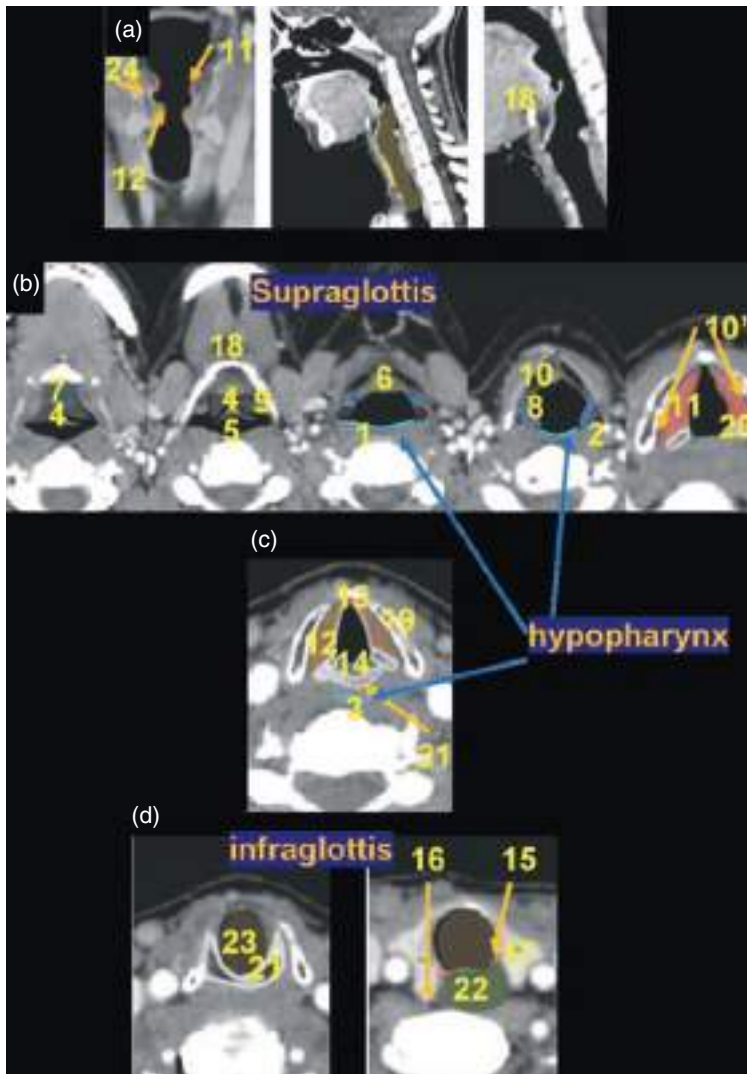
Larynx. (a) Coronal (left) and sagittal views (middle and right) of the larynx in the midline, with detail of the laryngeal ventricle and the pre-epiglottic space in the coronal and sagittal planes, respectively. (b) Axial contrast-enhanced CT images of the supraglottic space. (c) Axial noncontrast CT image at the level of the glottis. (d) Axial contrast-enhanced CT images at the infraglottic level. Hypopharynx: formed by 1, posterior pharyngeal wall; 2, pyriform sinus; 3, post-cricoid region. Supraglottis: 4, epiglottis with glossoepiglottic fold and valleculae located on both sides; 5, free edge of the epiglottis; 6, base of the epiglottis; 7, base of the tongue; 8, aryepiglottic folds; 9, pharyngoepiglottic fold; 10, pre-epiglottic space; 10', paraglottic space, which also extends to the glottis; 11, false vocal cords or bands. Glottis: 12, vocal cords, the vocal ligament lies more medial; 13, anterior commissure; 14, posterior commissure; 10', paraglottic space. Other structures: 22, esophagus; 17, thyroid gland; 16, parathyroid; 15, recurrent nerve. Bony and cartilaginous anatomy of the larynx: 18, hyoid bone; 19, thyroid; 20, arytenoid; 21, cricoid; 22, esophagus; 23, trachea; 24, laryngeal ventricle; 25, hypopharynx.
